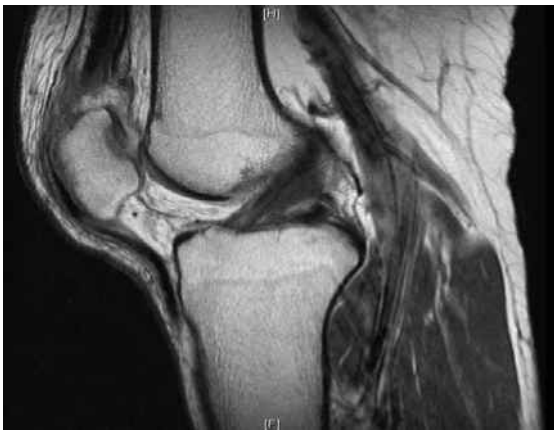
Sagittal PD-W MR image of the right knee shows a complete tear of the quadriceps tendon and an anterior cruciate ligament strain.
